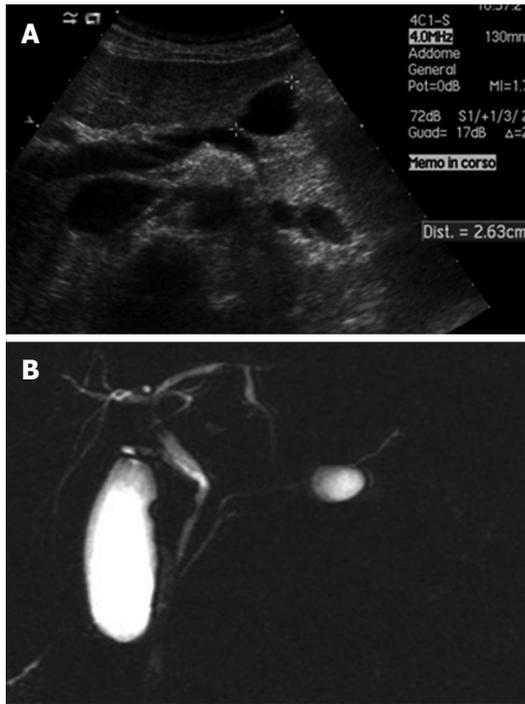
Unilocular serous pancreatic neoplasia. A: B-mode ultrasound shows a cyst in the body of the pancreas; B: Magnetic resonance imaging shows small cystic lesions in the body of the pancreas not communicating with the main pancreatic duct.
